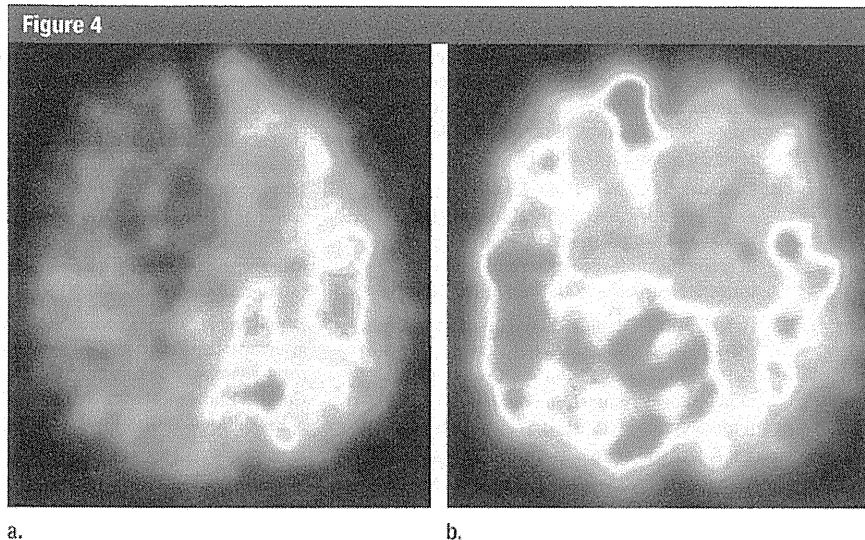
SPECT images in same patient as in Figure 1. (a) Preoperative image shows a decrease in CBF in the right cerebral hemisphere, in which hyperperfusion is observed on (b) image obtained immediately after CEA. This patient developed confusion and left motor weakness 3 days after surgery.
